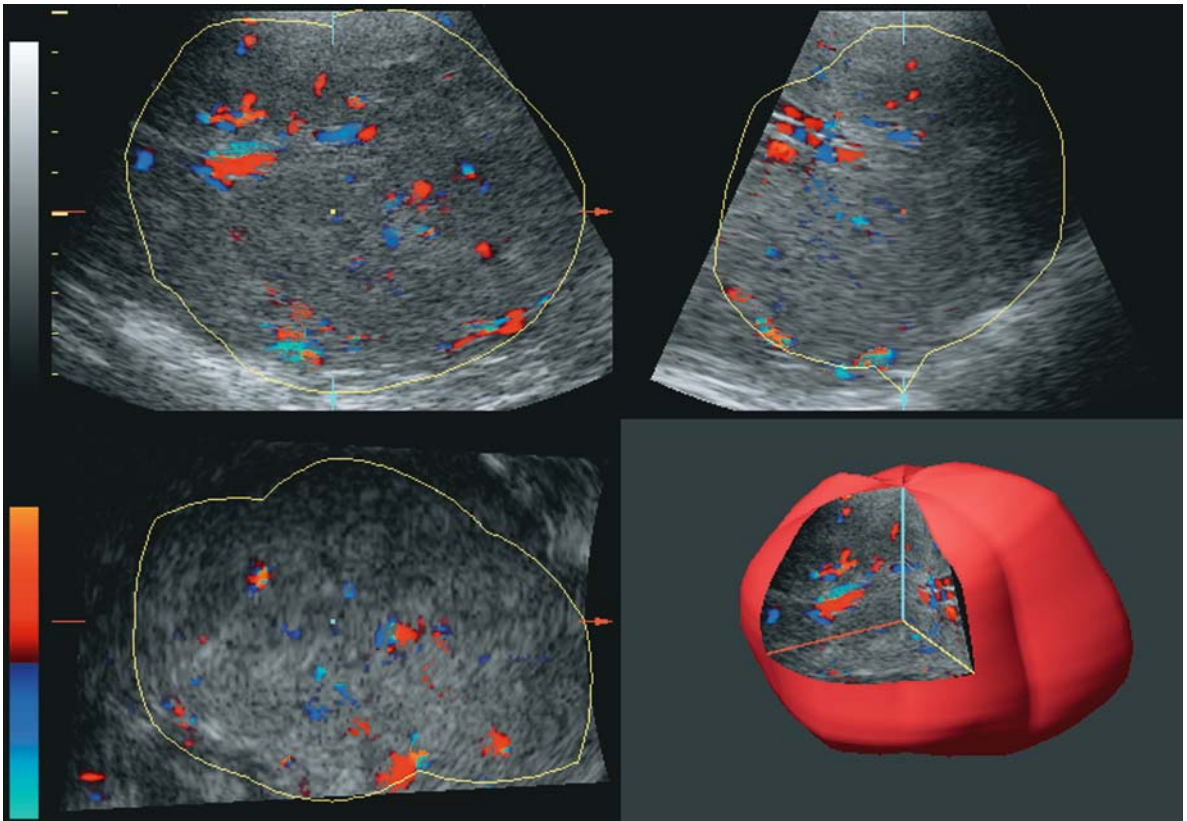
Three-dimensional Doppler was used to acquire volumes
